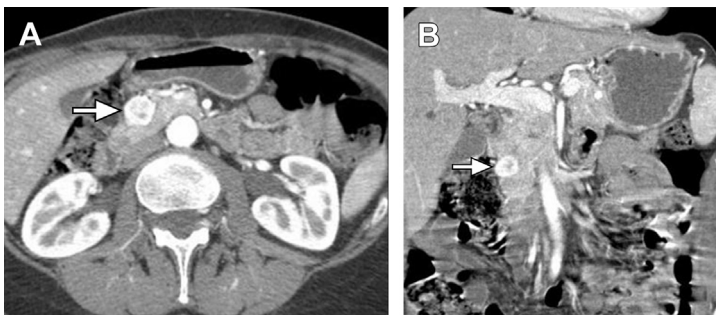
Pancreatic neuroendocrine tumor. (A) Axial and (B) coronal contrast-enhanced multi-detector computed tomography images in the pancreatic phase show an enhancing pancreatic tumor in the pancreatic head (arrow), which is enhancing more than the background pancreatic parenchyma consistent with a neuroendocrine tumor.
